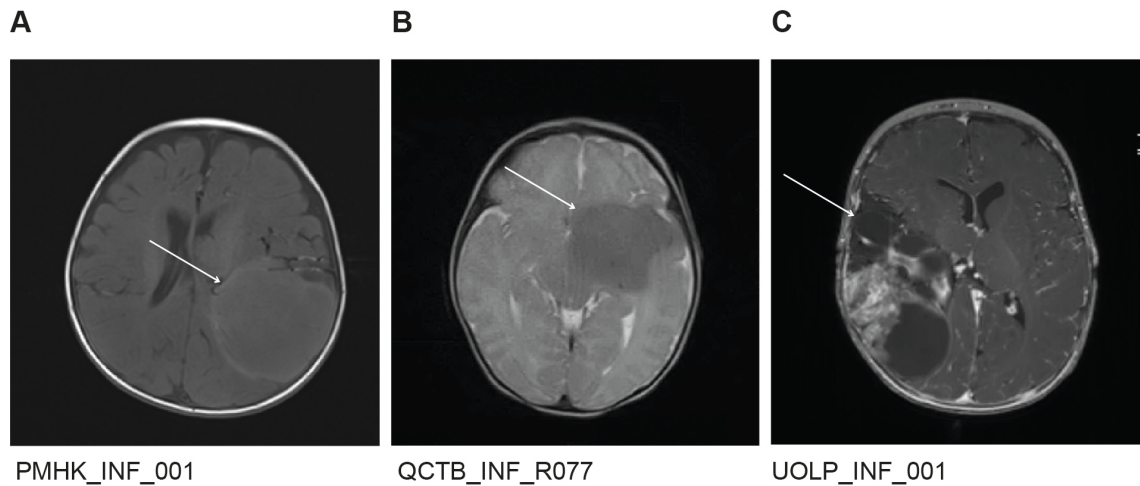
Representative MRI images of infantile tumours diagnosed as HGG in the cohort. A, PMHK_INF_001, T1 axial scan showing a large left-hemispheric lesion. B, QCTB_INF_R077, T2 axial scan showing a relatively well-defined mass in the left frontal lobe. C, UOLP_INF_001, T2 axial scan showing a large lesion in the right hemisphere showing solid and cystic components. White arrows indicate tumour.
